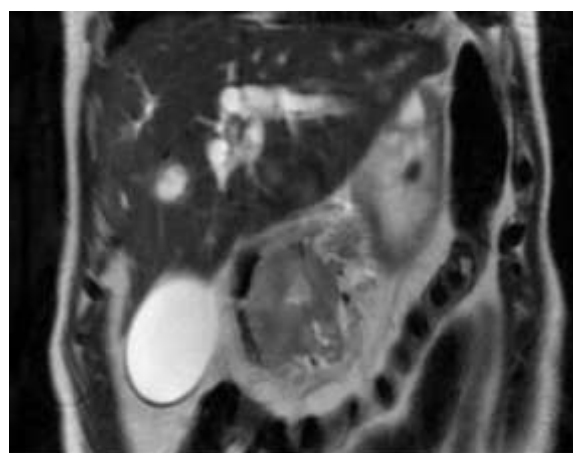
CE MRI of upper abdomen: Coronal plane: Pancreas head and neck neoplasm with with local infiltration of adjacent blood vessel and infiltration in duodenum, distance metastases (liver).
